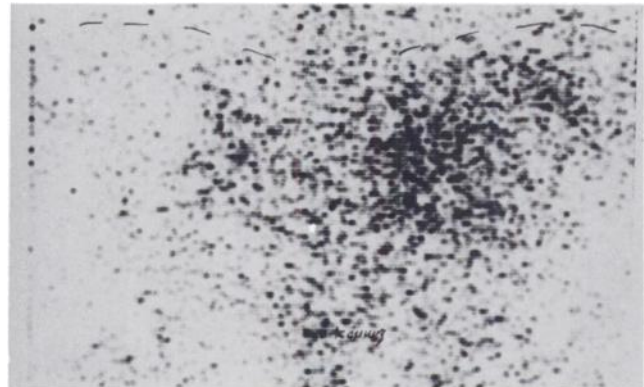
Case 6. ^{87m}Sr scintigram clearly visualizes tumor.
